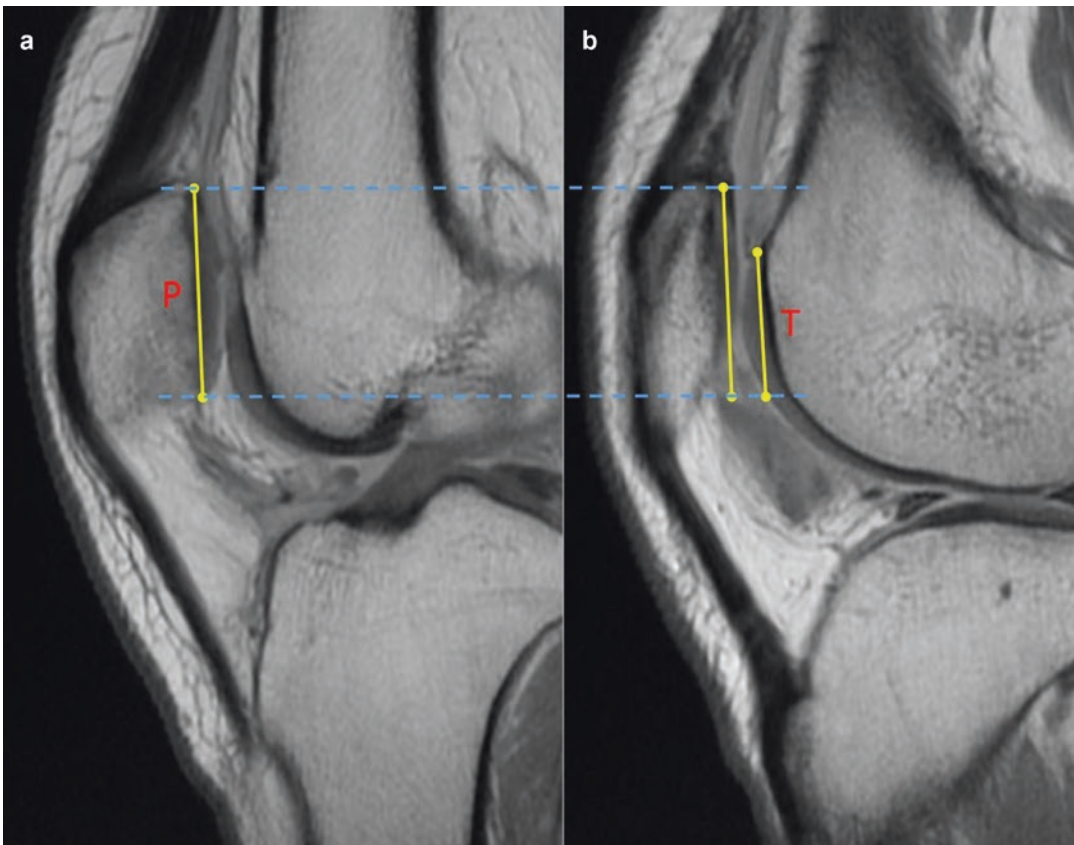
Measurement of sagittal patellofemoral engagement. Intermediate weighted sagittal MRI of the knee. The image (a) with the longest sagittal length of patellar articular cartilage is chosen and this length is measured (P). The line P is then transferred to the sagittal
